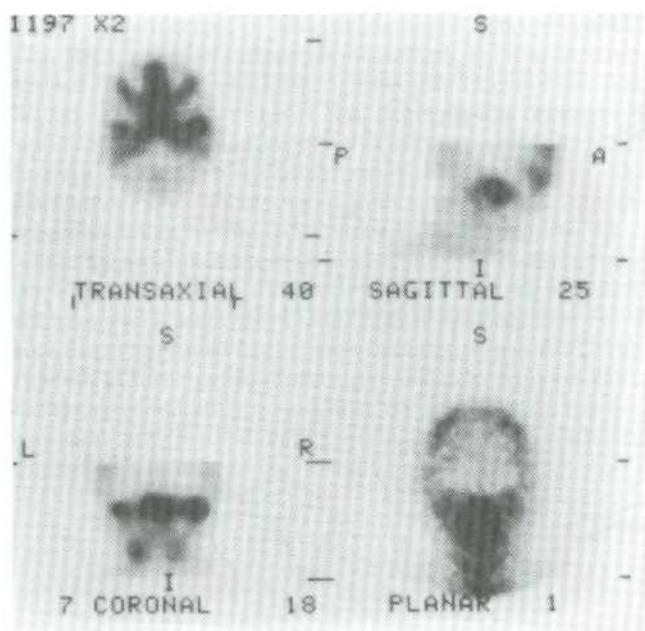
Single photon emission computed tomography (bone scan). Area of increased activity is apparent in both temporomandibular joints.
